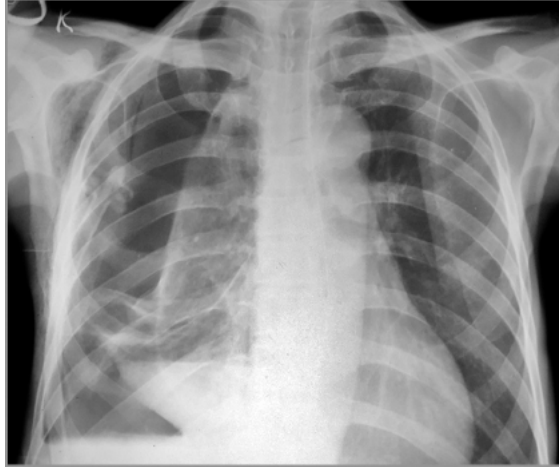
Chest X-ray PA view showing homogeneous opacity in the right hemithorax obliterating the costophrenic angle, pleural based suggestive of loculated pleural effusion.
